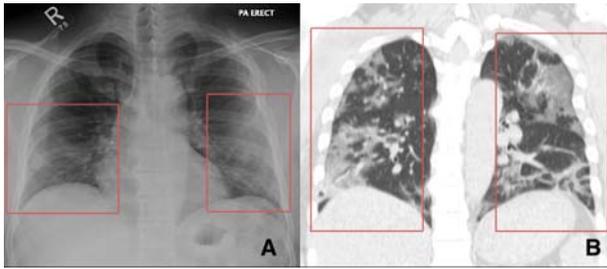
Chest radiograph (A) and coronal CT (B) images of a 42-year-old man with a one-week history of fever. The true extent of lung involvement is better appreciated on the CT compared to the CXR (red box) in this patient with COVID-19.
